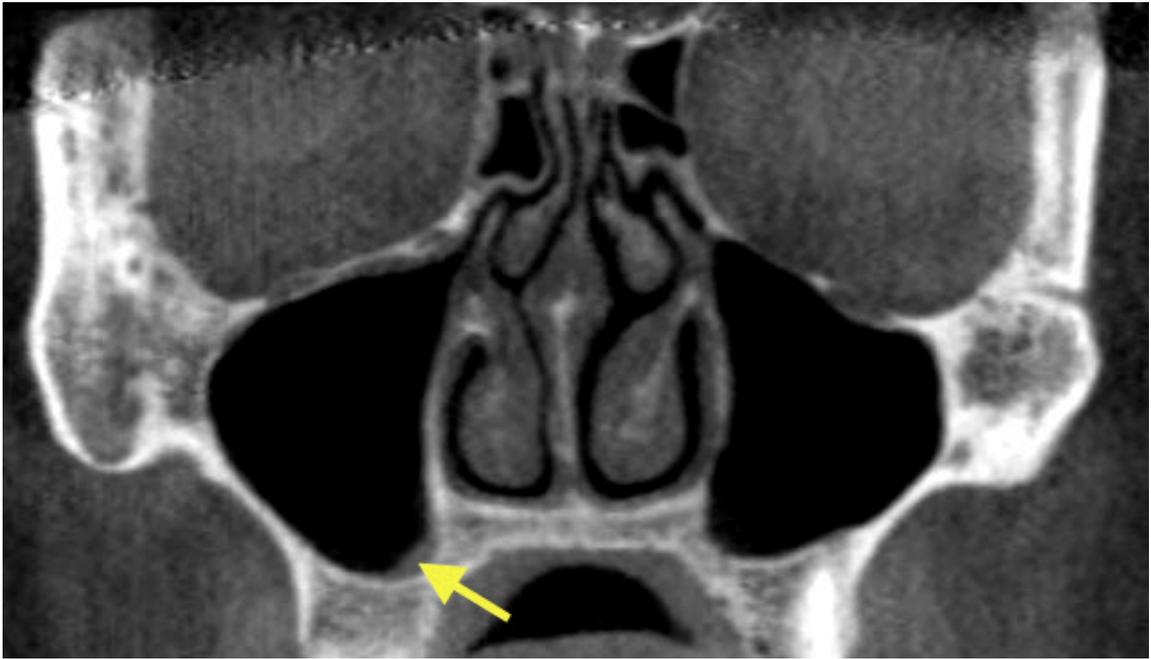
CBCT coronal section showing a mucus retention pseudocyst (arrow) in the right maxillary sinus
